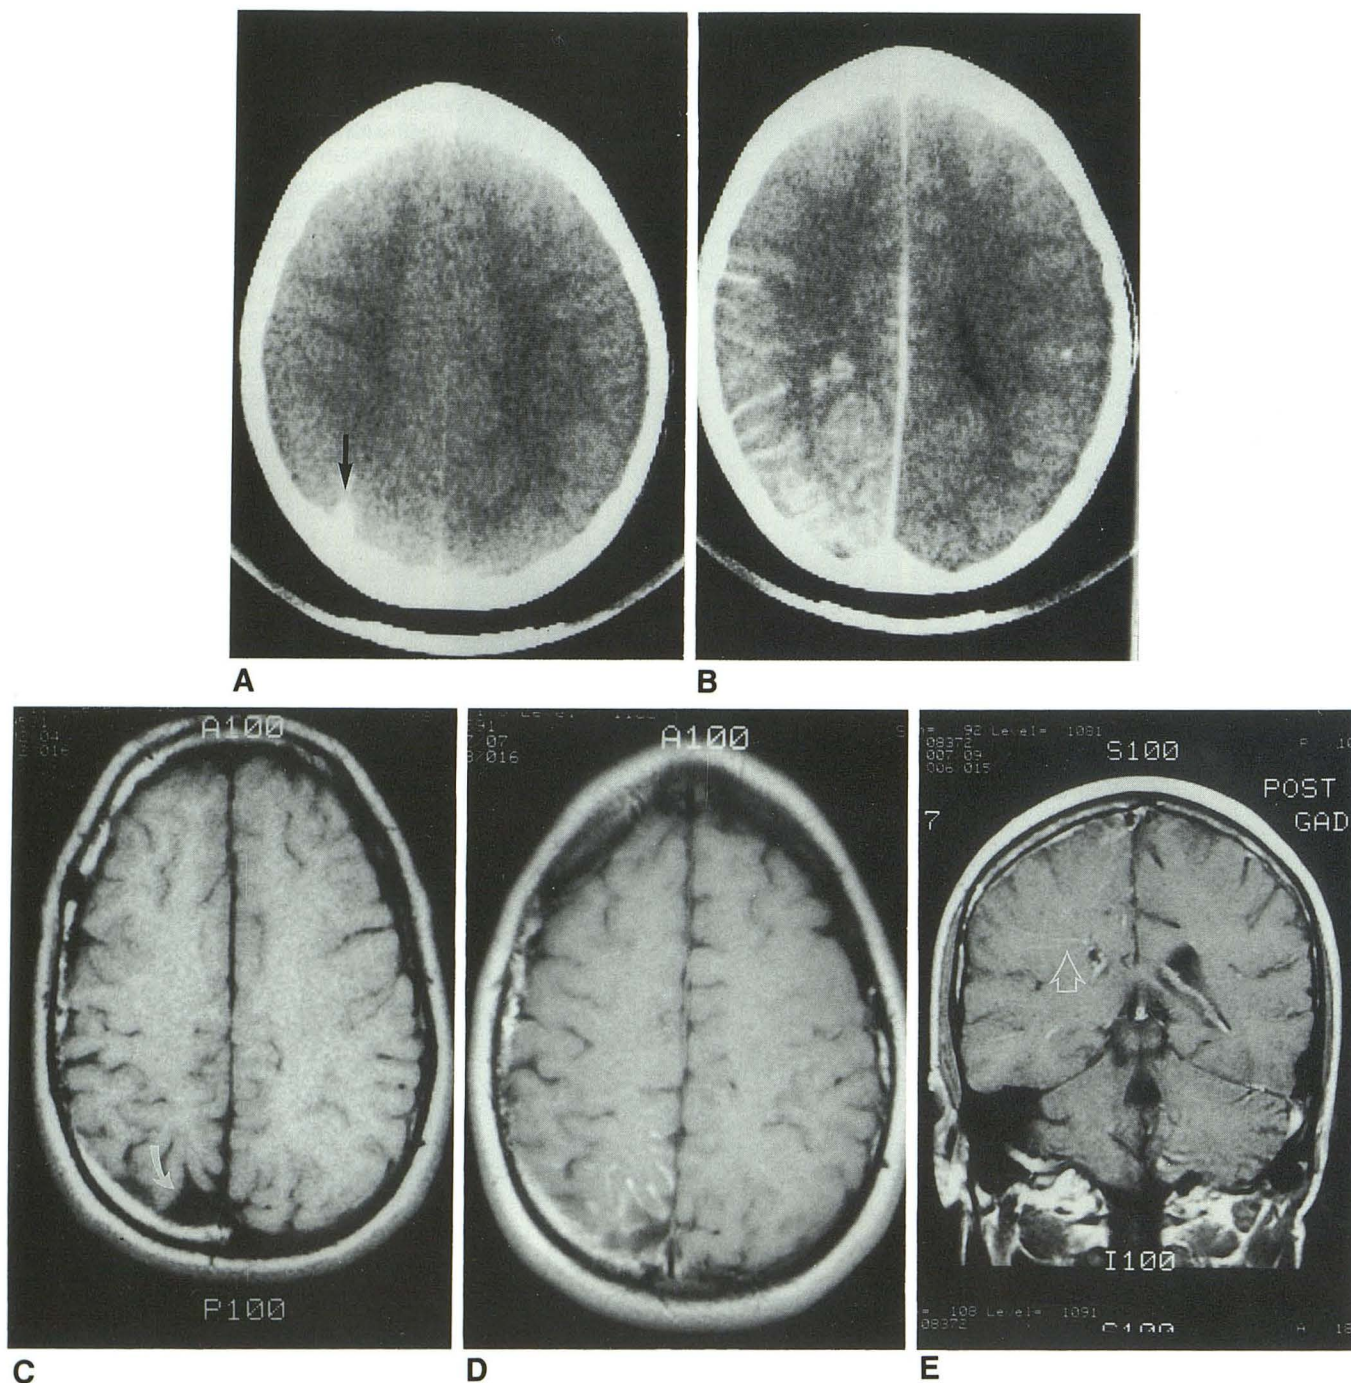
Case 5. A, Noncontrast CT with focus of calcification in right parietal lobe (*arrow*) without significant atrophy. B, Contrast CT with diffuse pial enhancement in right hemisphere within angioma. C, Noncontrast axial T1W MR image (10 years following CT) demonstrating mild right parietal atrophy (*curved white arrow*). D, Contrast axial T1W MR image demonstrating enhancement adjacent to areas of atrophy. Note marked regression of pial angioma as compared to previous contrast CT. E, Contrast coronal T1W MR image demonstrating enhancement within deep veins (*open arrow*) of involved hemisphere.
